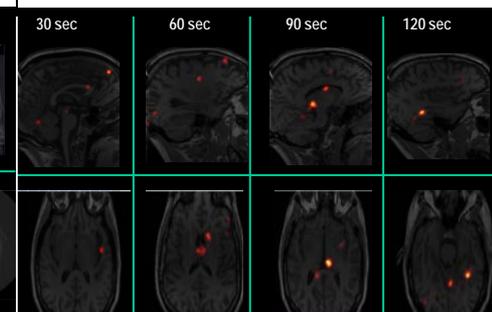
Dynamic ratio SPECT co-registered to MRI demonstrates transient hyper-perfused regions over 120 sec.
